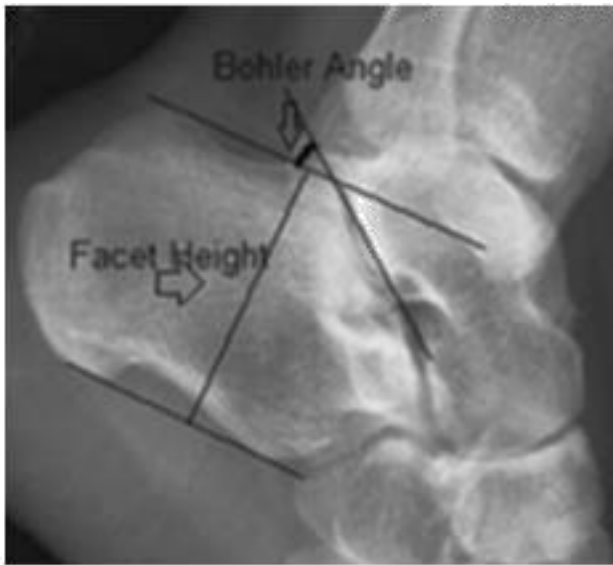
The Bohler's angle and the facet height (lateral view X-ray) (11)
